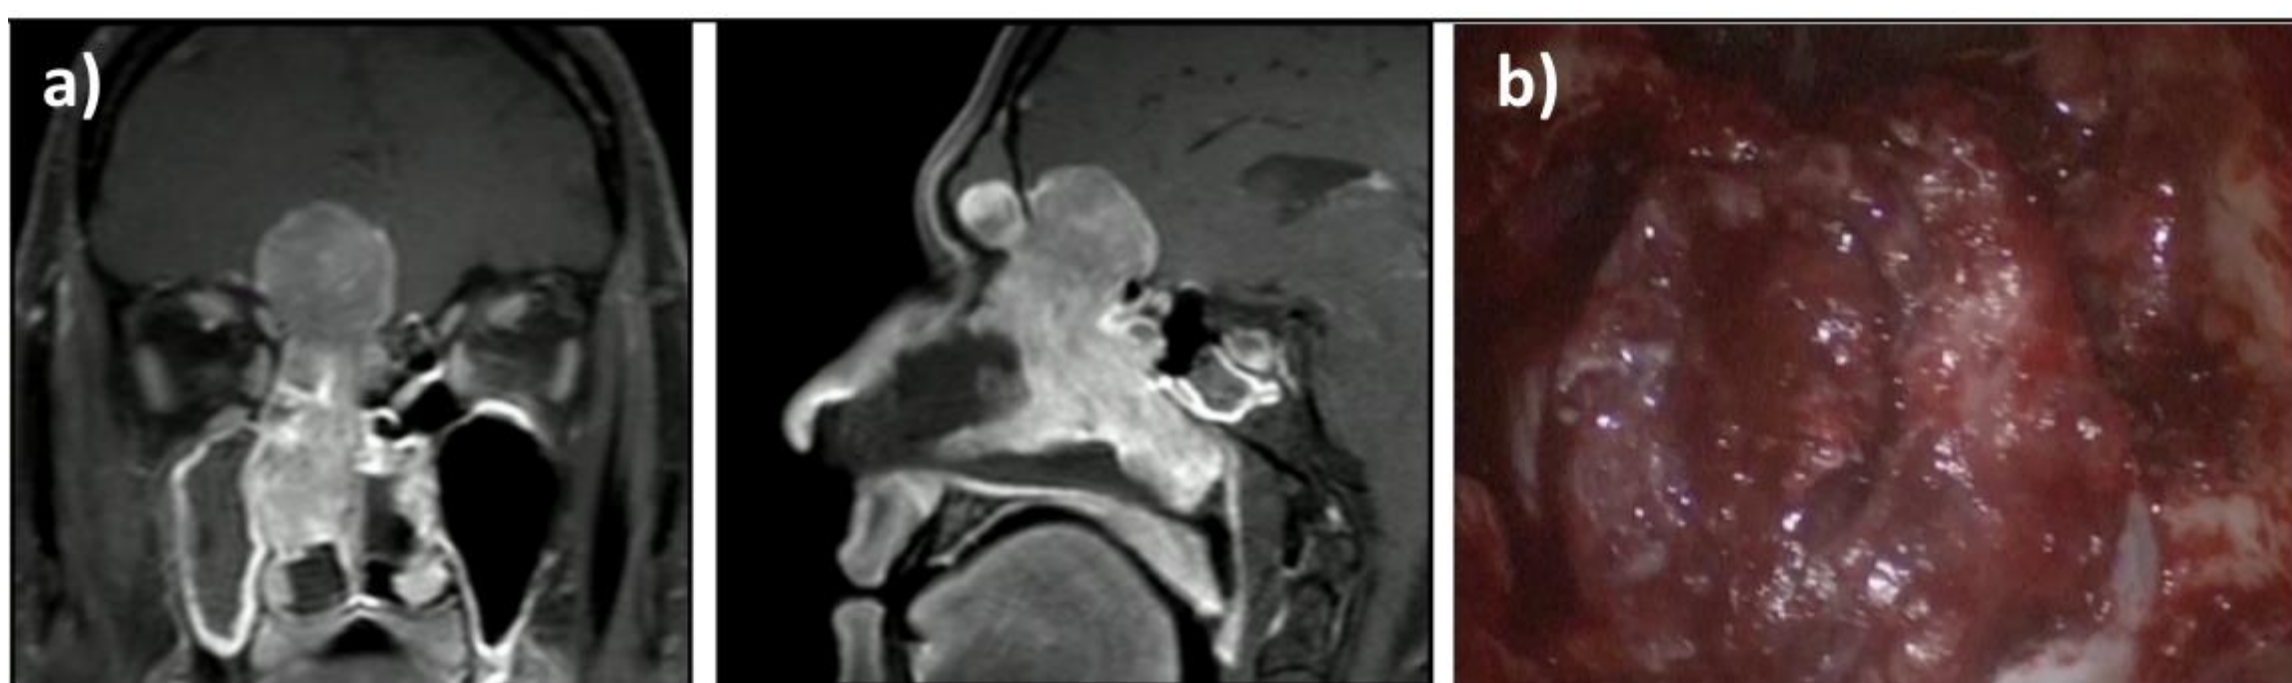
a) Pre-operative MRI. b) Intra-operative view.
